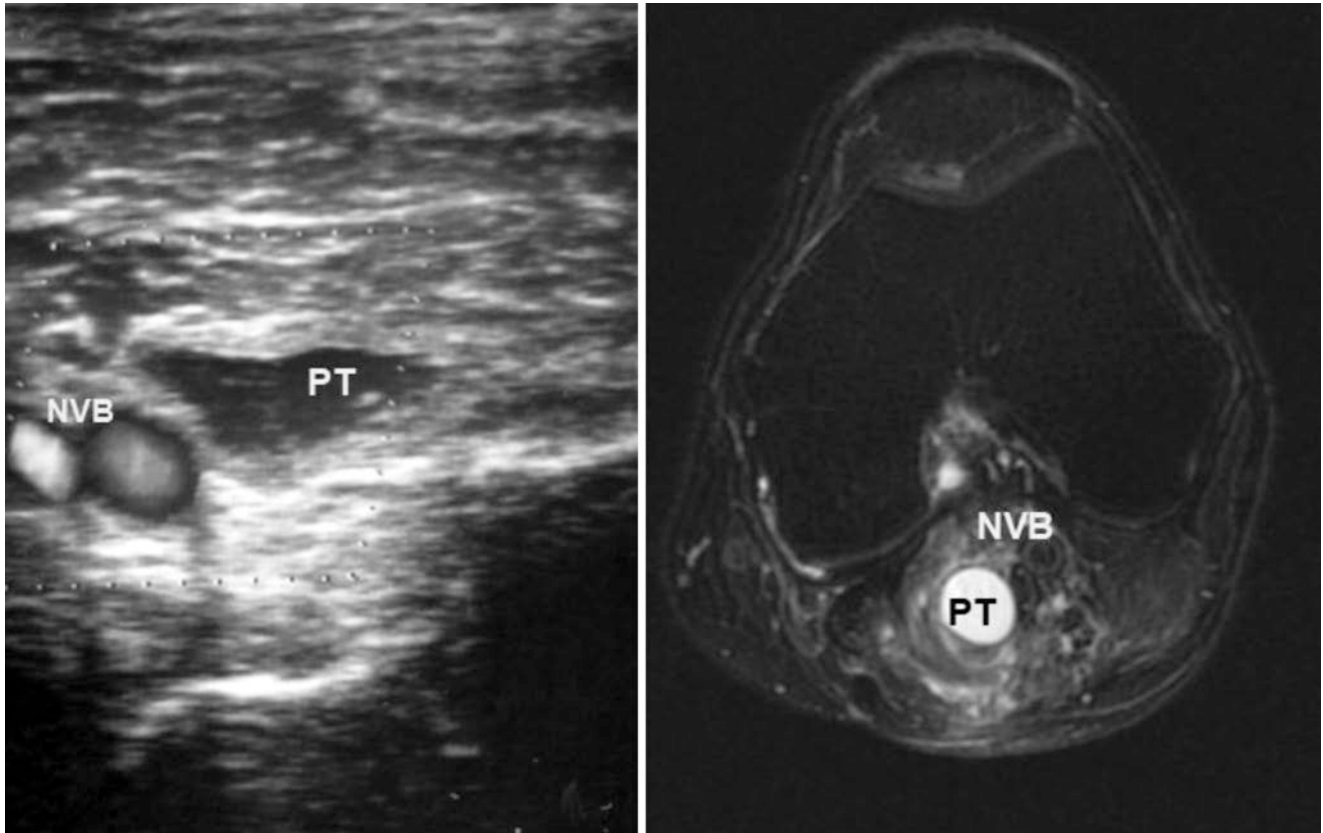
Ultrasound examination (left) and axial MRI scan (right) of the popliteal cyst (PT). The lateral wall of the cyst is located in a close proximity to the popliteal neurovascular bundle (NVB). Atypical location of the cyst is visible on MRI
